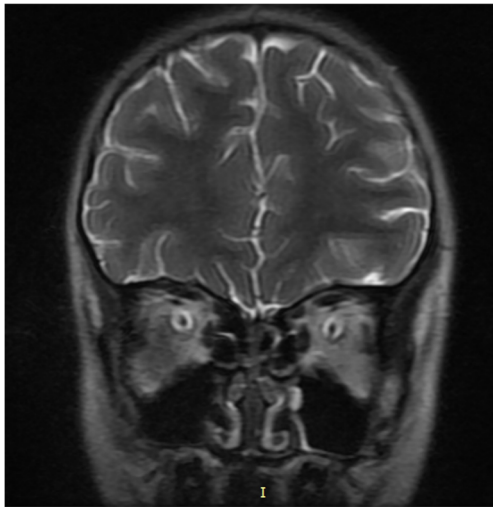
Coronal T2-weighted image shows a target sign
